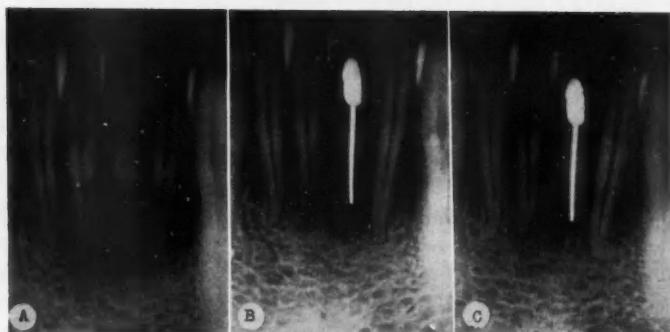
Roentgenograms made of a mandibular left central incisor obturated with the single silver cone technique. *A*, At initiation of therapy. *B*, At completion of obturation. *C*, One year after completion of therapy, demonstrating complete resolution of apical pathosis.
